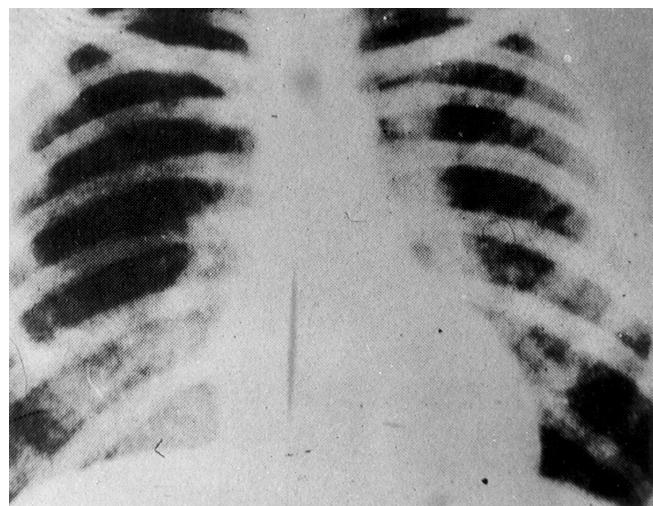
X-ray examination of the heart of Mr E. Z. when aged 23 years.
